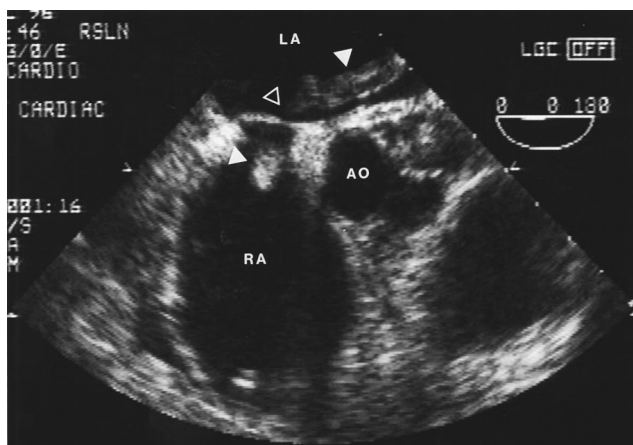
Transesophageal view of an elongated thrombus crossing the interatrial septum with its major portion in the left atrium (LA, left atrium; RA, right atrium; AO, aorta).
